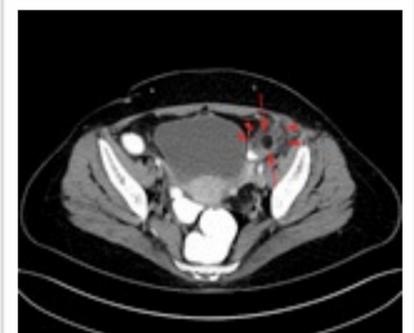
Axial contrast-enhanced CT scans of second patient clearly shows a round pericolonic lesion with fat attenuation surrounded by a hyperattenuating ring (arrows). There is also perilesional inflammation (arrowheads).
